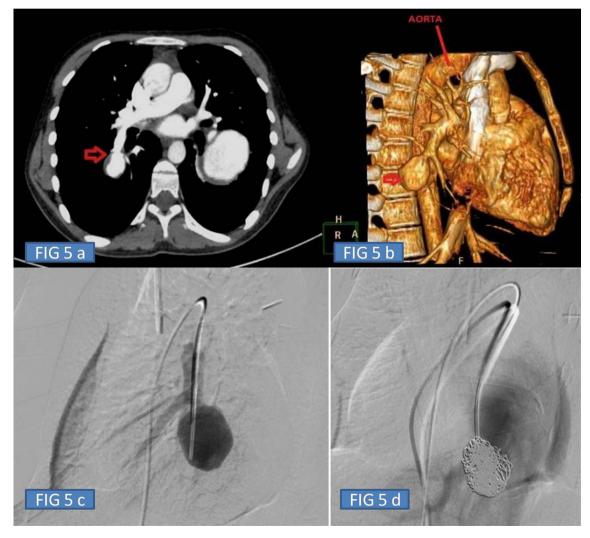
a. CT axial MIP image showing a rounded aneurysm from right descending pulmonary artery (arrow). Aneurysm is also seen on left side which was managed by lobectomy. b. Volume Rendered CT image showing the right descending pulmonary artery aneurysm (arrow) and one arrow showing the aorta. c. DSA image showing catheter tip in aneurysmal sac which is filled with contrast. d. DSA image showing coil mass within the aneurysm which is obliterating the aneurismal sac.
